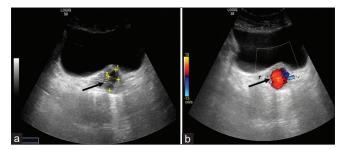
Transabdominal USG shows a well-defined thick-walled anechoic cystic lesion (arrow a) in the region of the vaginal vault with the turbulent flow (arrow b) on Doppler imaging, suggestive of arterial pseudoaneurysm. UB: Urinary bladder, USG: Ultrasonography
